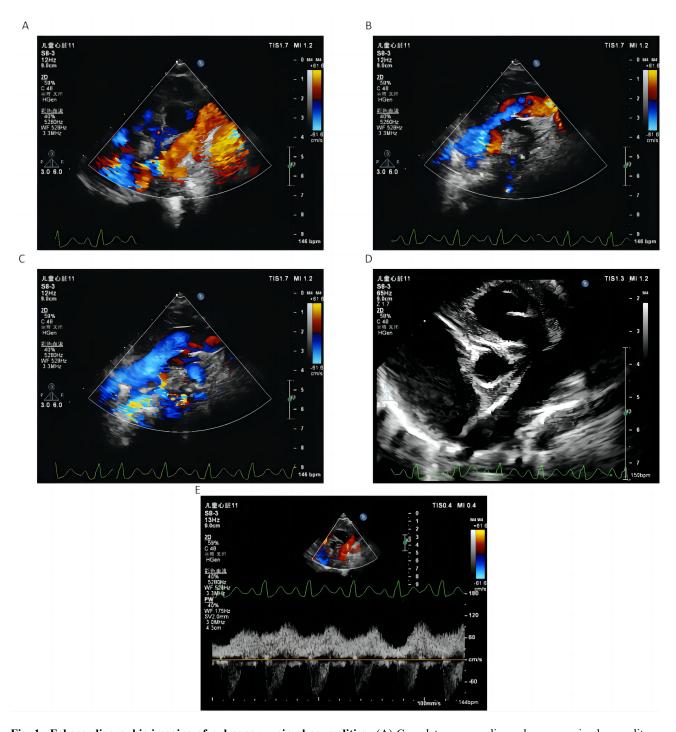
Echocardiographic imaging of pulmonary vein abnormalities. (A) Complete supracardiac pulmonary vein abnormality – color Doppler image showing a vertical vein. (B) Complete supracardiac pulmonary vein abnormality – color Doppler image showing vertical vein flexion towards the right atrium. (C) Complete supracardiac pulmonary vein abnormality – color Doppler image of vertical venous drainage to the right atrium. (D) Complete supracardiac pulmonary vein abnormalities—two-dimensional echocardiographic images of vertical veins. (E) Complete supracardiac pulmonary vein abnormality—pulsed wave Doppler spectrum of the veins in the vertical direction.
